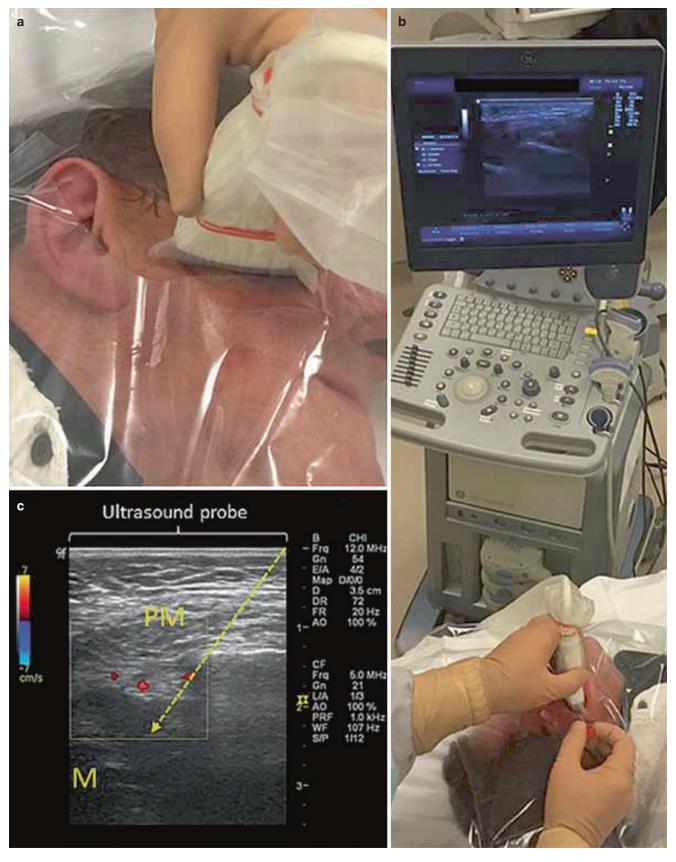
(a) The ultrasound probe is positioned below the zygomatic arch with cephalad angulation in order to visualize the target area below the zygoma. (b) The needle is placed in-line with the transducer from lateral to medial. (c) The ultrasound image is a transverse view.
